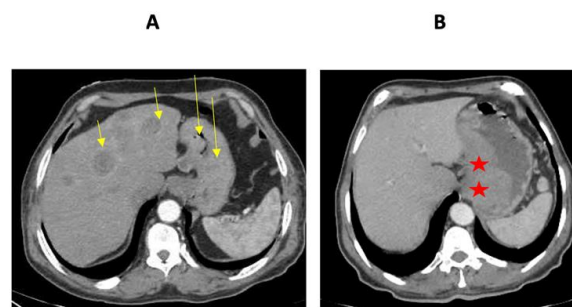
CT scans of two patients with Non-SRCC
